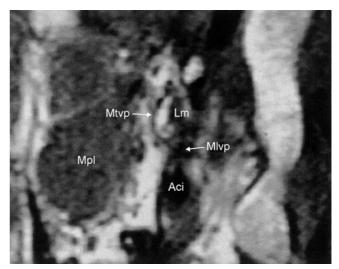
T1-weighted MR image angled 45° from the sagittal plane and 30° from the horizontal plane. Mtvp = tensor veli palatini muscle, Lm = medial lamina of tubal cartilage, Mlvp = levator veli palatini muscle, Mpl = lateral pterygoid muscle, Aci = internal carotid artery. Note the typical shape of the Ostmann fat pad between the Mtvp and Lm.
